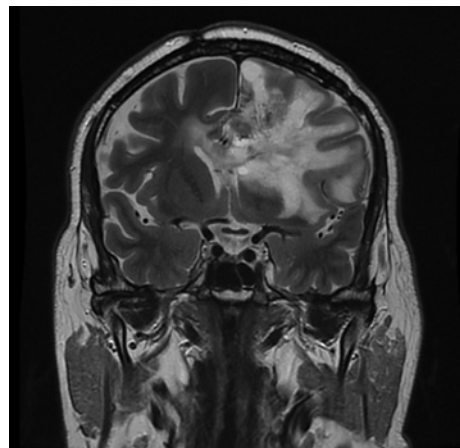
August 2021, MRI coronal T2 FSE, progression disease.
